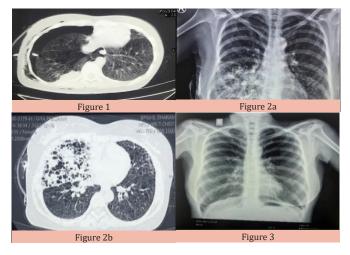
Initial CT Chest showing right sided pneumothorax; Figure 2a and 2b showing right sided consolidation with patchy ground glass opacity after instillation of Povidone iodine; Figure 3 showing spontaneous resolution of right sided pneumonitis.
